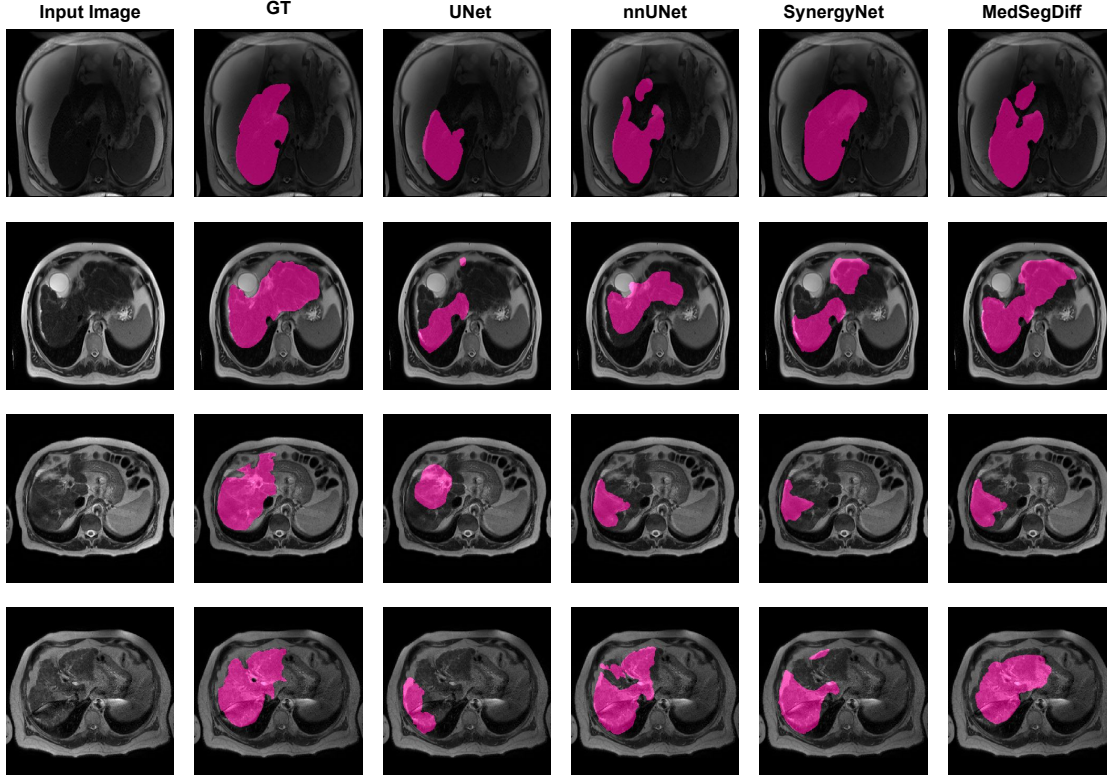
The figure shows the qualitative results examples of different models on segmenting mild and severe cirrhosis from abdominal T2-weighted MRI scans. From the figure, it can be observed that MedSegDiff is the best choice.
